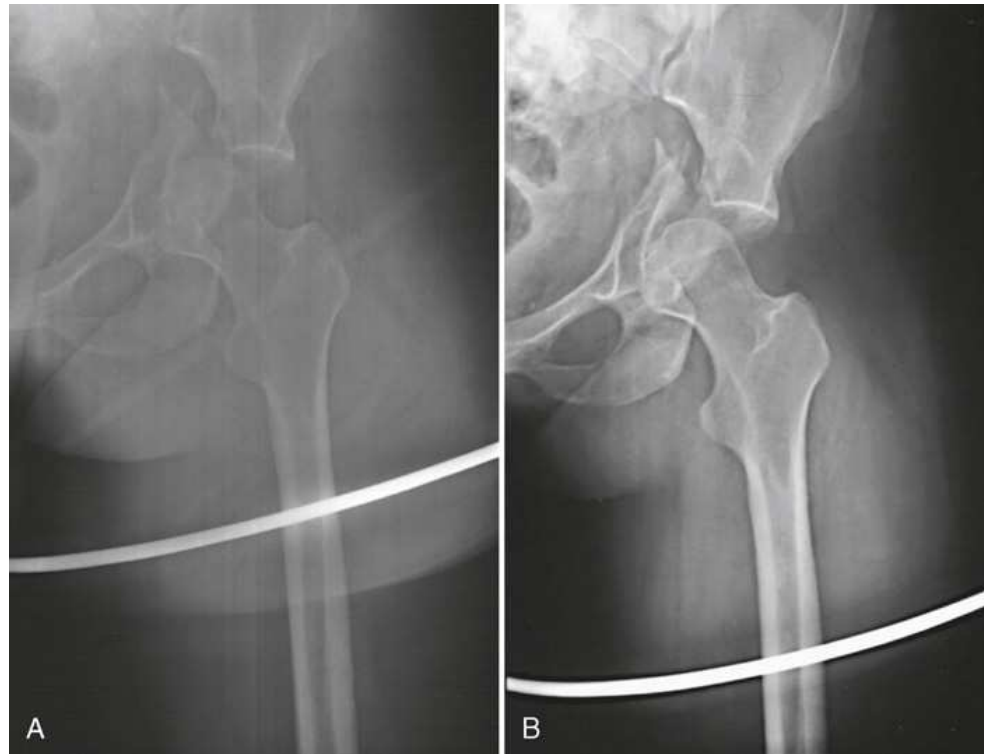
Mobile radiograph of proximal femur and hip, showing comminuted fracture of left acetabulum. (A) Poor-quality radiograph resulted when grid was transversely tilted far enough to produce significant grid cutoff. (B) Excellent-quality repeat radiograph on the same patient, performed with grid accurately positioned perpendicular to central ray.
